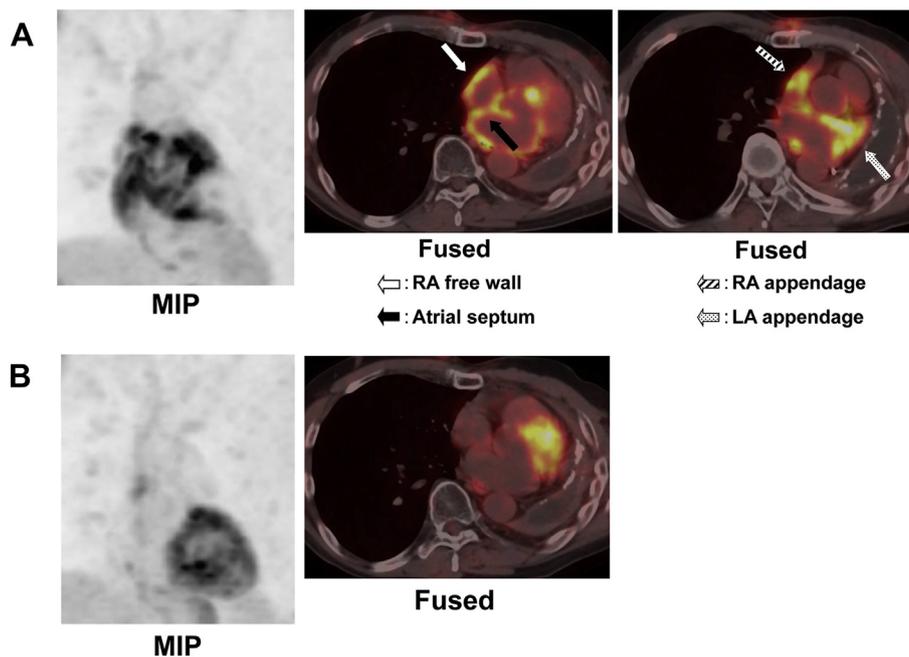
A male patient in his 50s had undergone a lung cancer surgery 14 years previously, and was followed up by several PET/CT examinations. He had severe atrial tachyarrhythmia when PET/CT imaging was performed, prior to ablation therapy. (A) Avid accumulation of FDG was found in the right atrium (RA) appendage and free wall, atrial septum, left atrium (LA) appendage, and LA anterior and posterior walls (RA target-to-background ratio [TBR]: 5.00; LA TBR: 5.85). (B) Ten months later, he received additional treatment with cardioversion for relapsed atrial fibrillation, which was effective. Normal sinus rhythm was restored. At the 1-year PET/CT follow-up study, no FDG uptake was observed in either atrium (RA TBR: 1.29; LA TBR: 1.71). MIP indicates maximum intensity projection.
